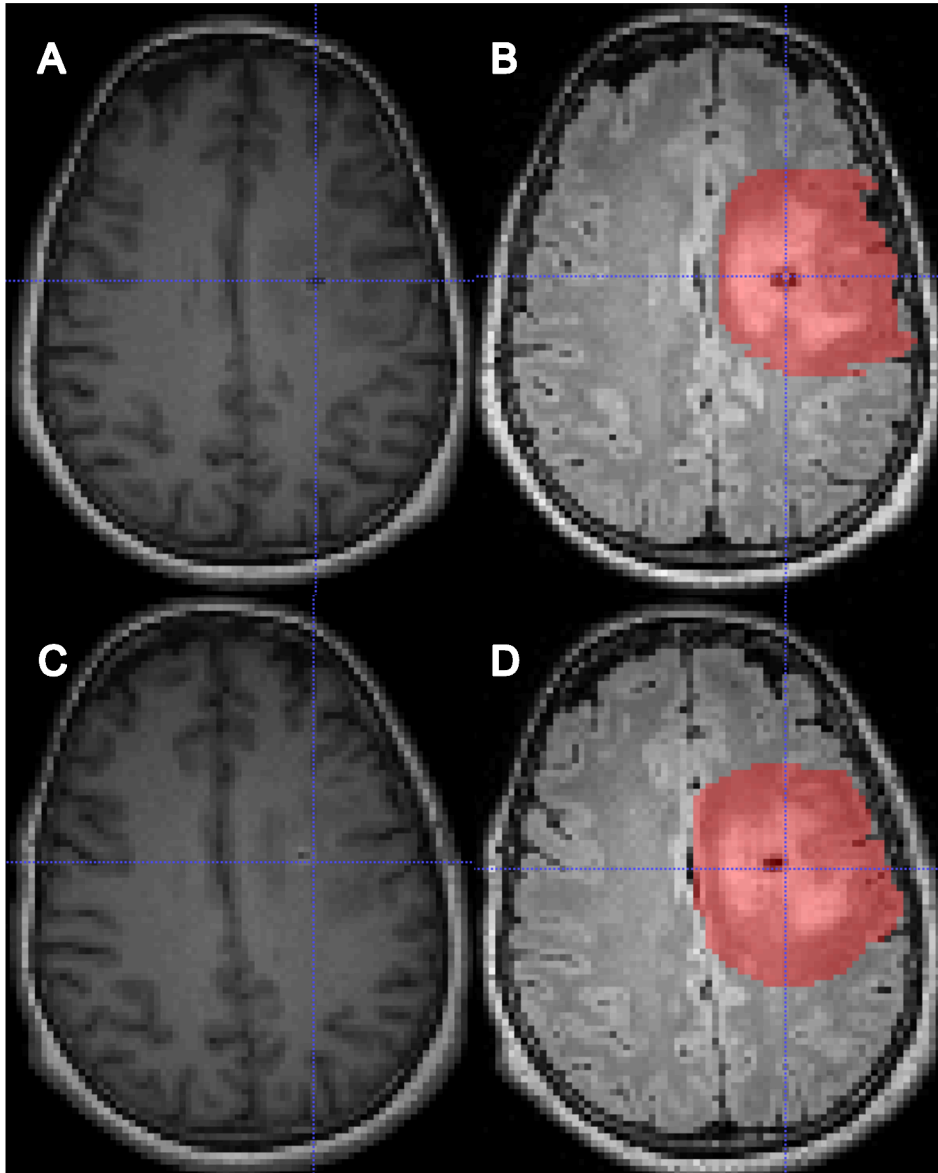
A MRI T1 (left) and aligned FLAIR (right) with edema VOI (in red overlay), before (A,B) and after (C,D) surgical intervention.
